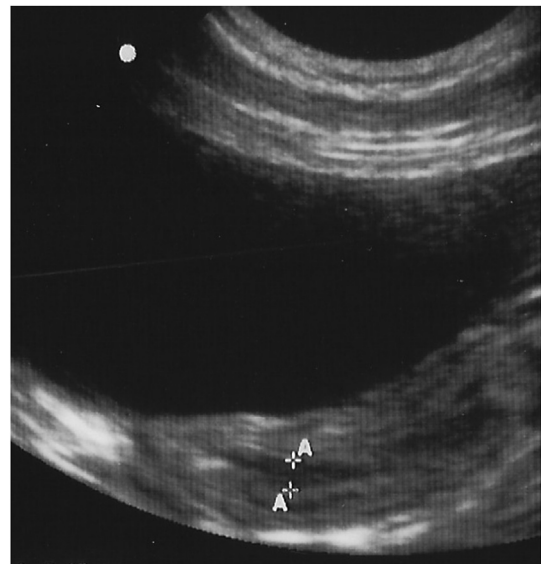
Ultrasound image of a bitch in late estrus showing the uterine body positioned adjacent to the bladder. The lumen of the uterus contains anechoic fluid (markers).
